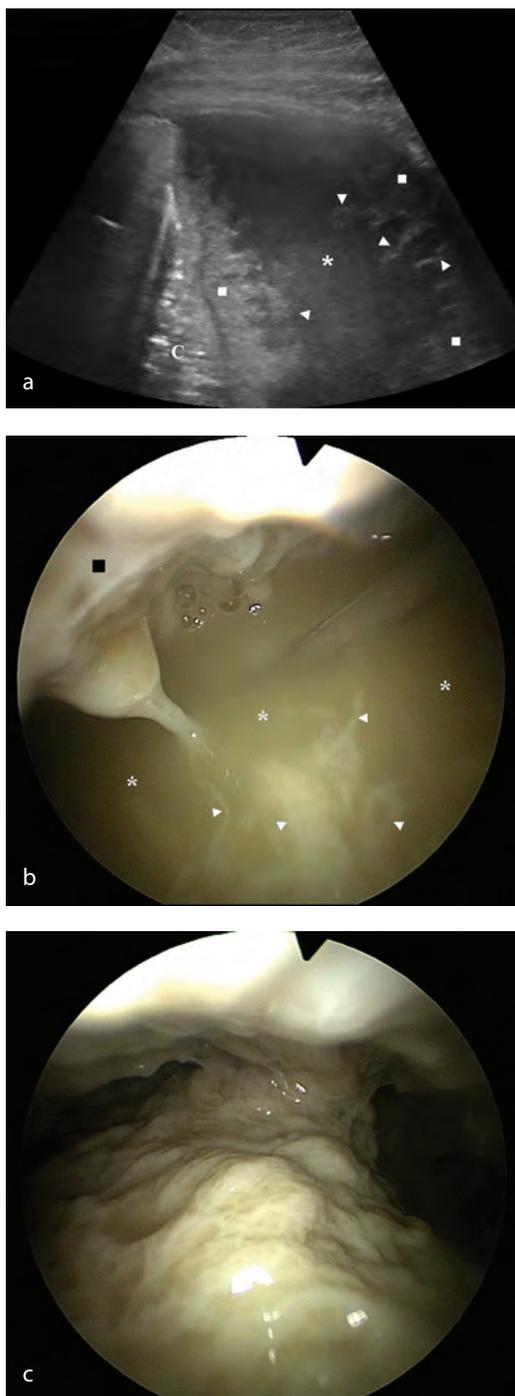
A 16-year old boy was provided with ambulatory care for 9 days and antibiotic therapy for a week. On admission he was dyspneic, febrile (38.7°C), and was coughing heavily, with oxygen saturation 91%-97%, and auscultatory finding of decreased breath sounds on the left. Lung ultrasound was performed on admission and video-assisted thoracoscopic surgery (VATS) the next day. There was a complete match of lung ultrasound (a) and VATS (b) findings of massive dense pleural effusion (*), with thick fibrin layers on both visceral and parietal pleural surfaces (□), and numerous fibrin filaments and strands floating within the pleural effusion (arrow heads). C - consolidation. c) VATS showing an extensive fibrinous coating of both visceral and parietal pleural surface after evacuation of the pleural effusion.
